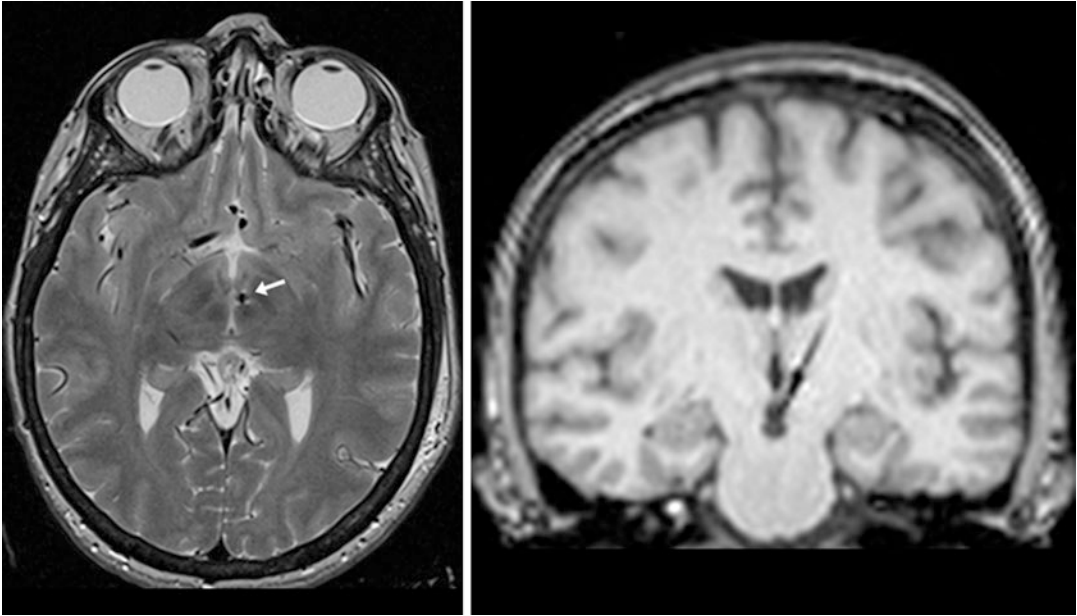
DBS lead location in the left VTA on axial (left) and coronal (right) MRI slices. (From Akram et al. [3]. Reprinted with permission from Wolters Kluwer Health, Inc)
